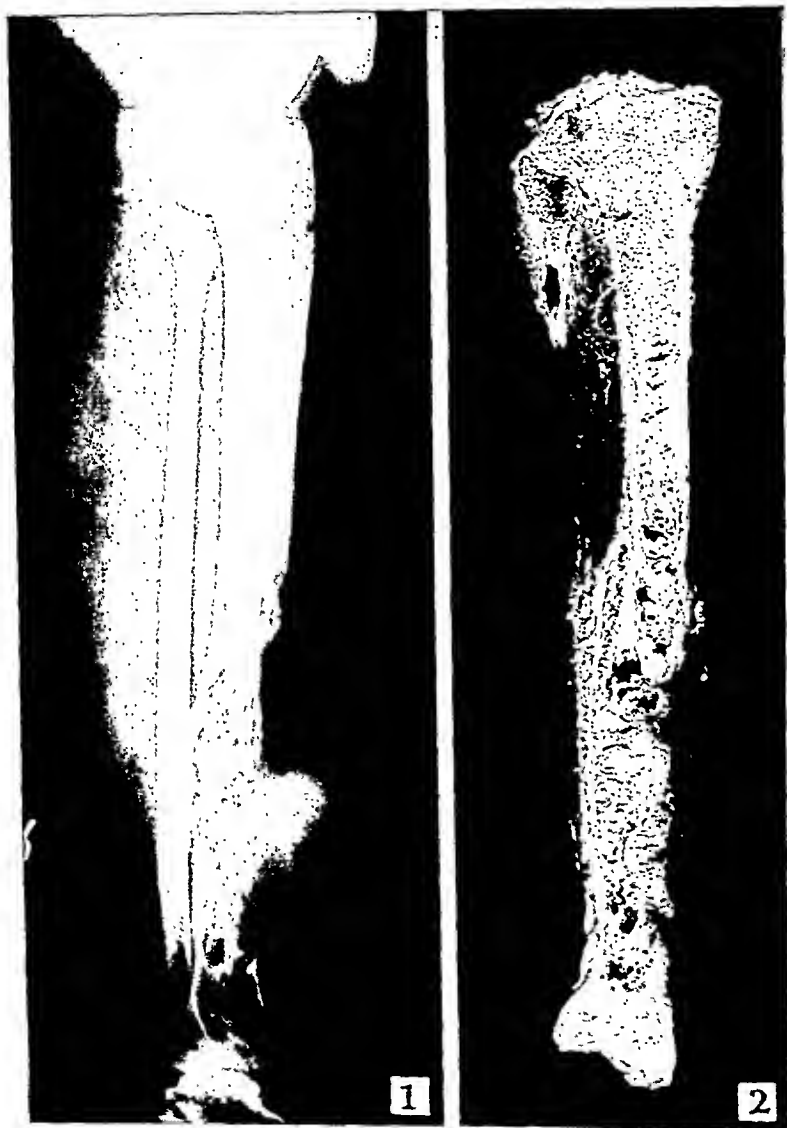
Roentgenogram of right leg, showing extensive destruction of tibial shaft and a soft tissue mass.
